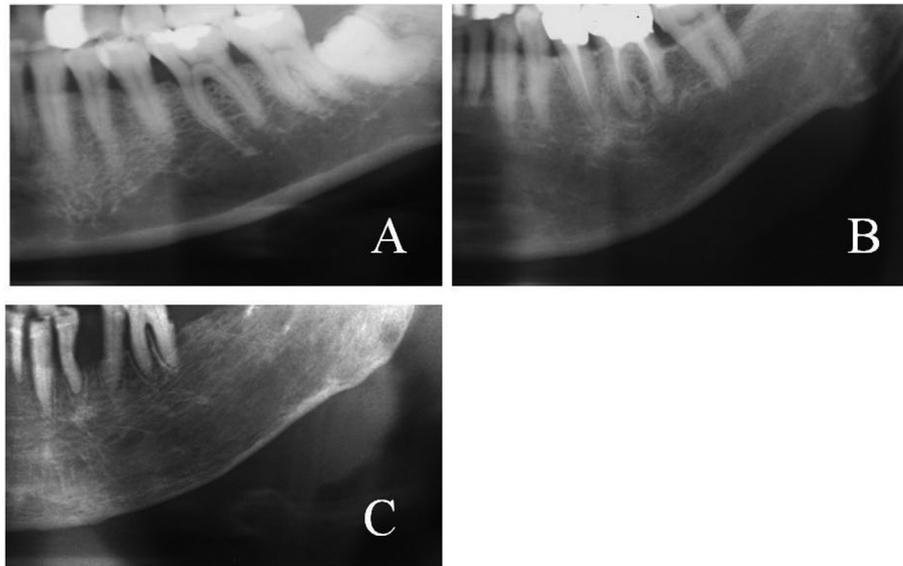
Mandibular cortical shape on panoramic radiographs. (A) Normal cortex: the endosteal margin of the cortex is even and sharp on both sides; (B) mildly to moderately eroded cortex: the endosteal margin shows semilunar defects (lacunar resorption) or appears to form endosteal cortical residues; (C) severely eroded cortex: the cortical layer forms heavy endosteal cortical residues and is clearly porous.
